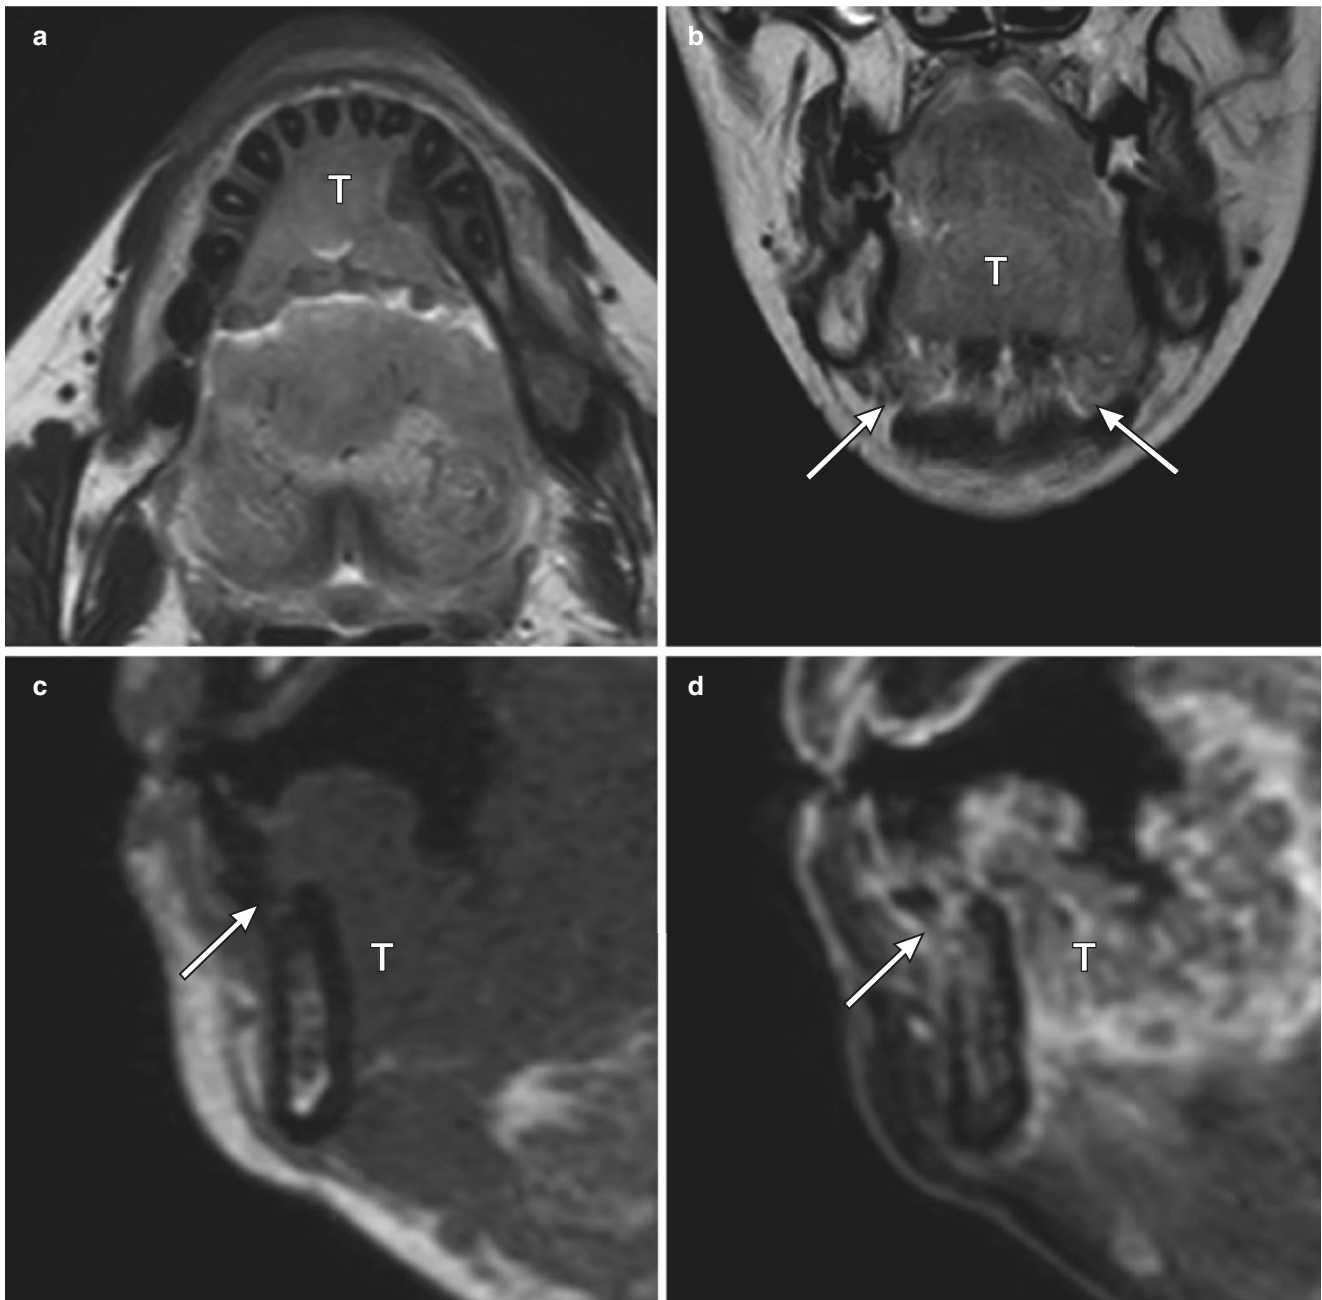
A 55-year-old woman with squamous cell carcinoma of the oral floor (anterior type). (a) Axial T2-weighted image shows the tumor (T) is located anterior part of the floor of the oral cavity. (b) Coronal T2-weighted image shows bilateral genioglossus muscle is replaced by
